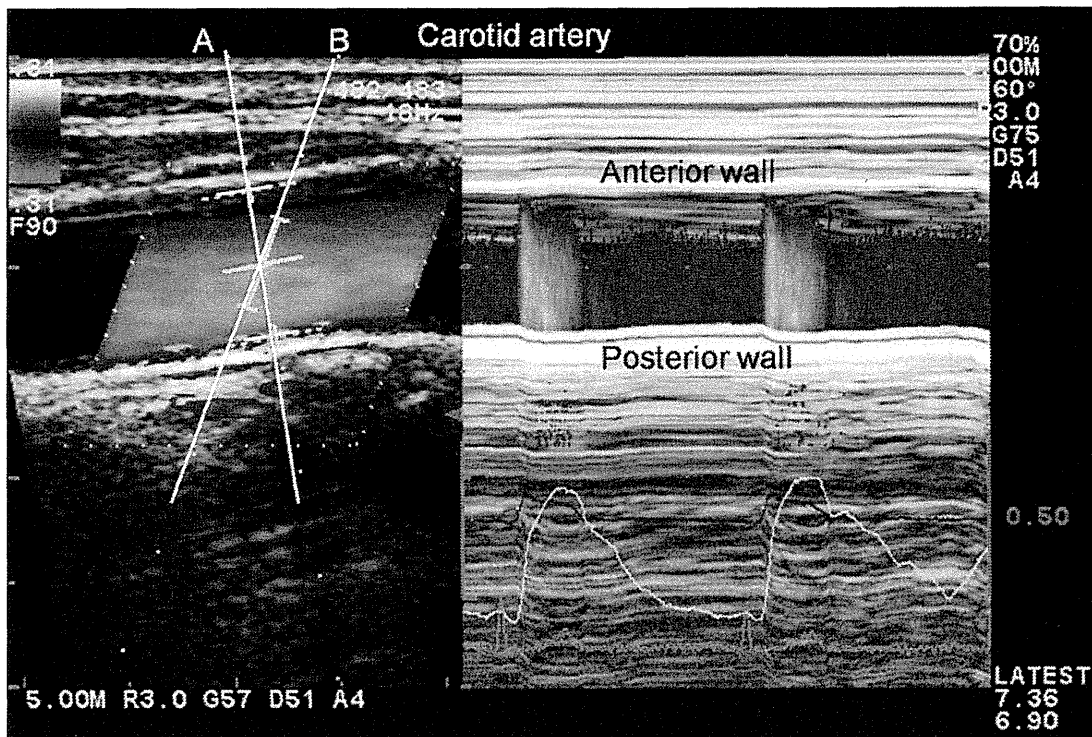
Simultaneous measurements of diameter-change waveform and blood flow velocity. View on the monitor during the measurements Left color Doppler/B-mode long-axis view of the common carotid artery. *Line A* and *B* indicate the ultrasonic beam for echo-tracking and for blood flow velocity measurement, respectively. By setting the tracking positions displayed as small orange bars on the echo tracking beam (*line A*) to arterial walls, echo tracking
